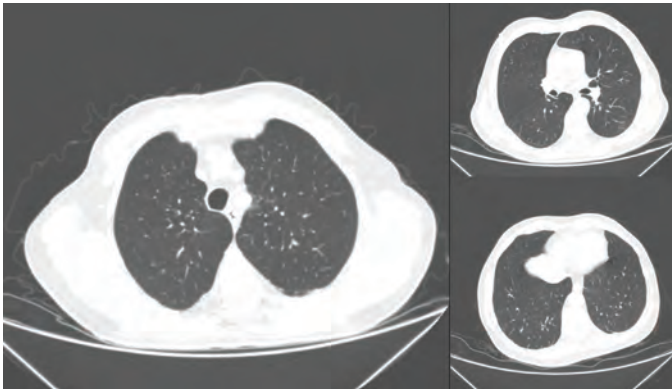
Patient's thorax computed tomography scans on the 14th day of hospitalization
